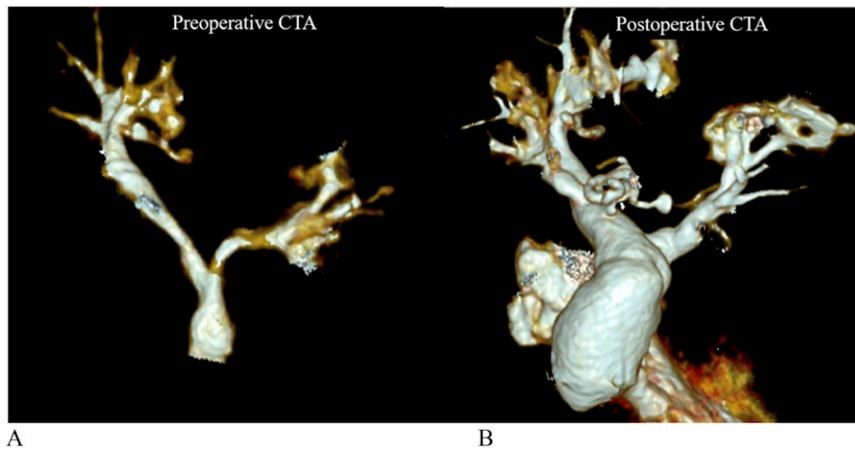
Branch pulmonary arteries as shown by 3D reconstruction of the computed tomographic (CT) scan (A) preoperatively and (B) after reconstruction.
